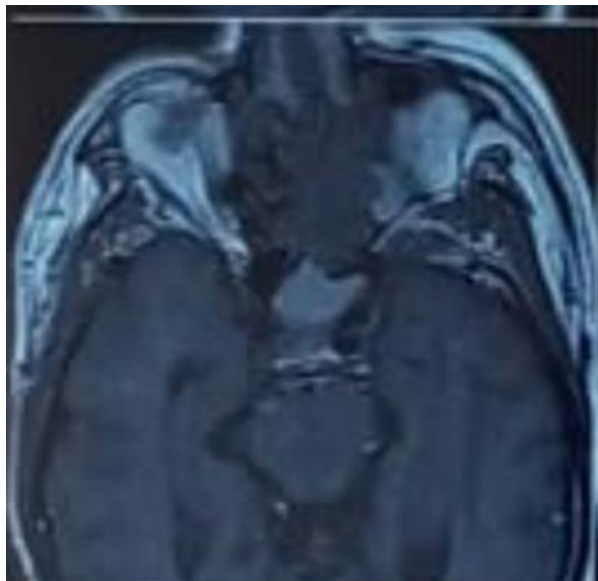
MR images of a tumour involving the right nasal cavity the left nasal cavity.
